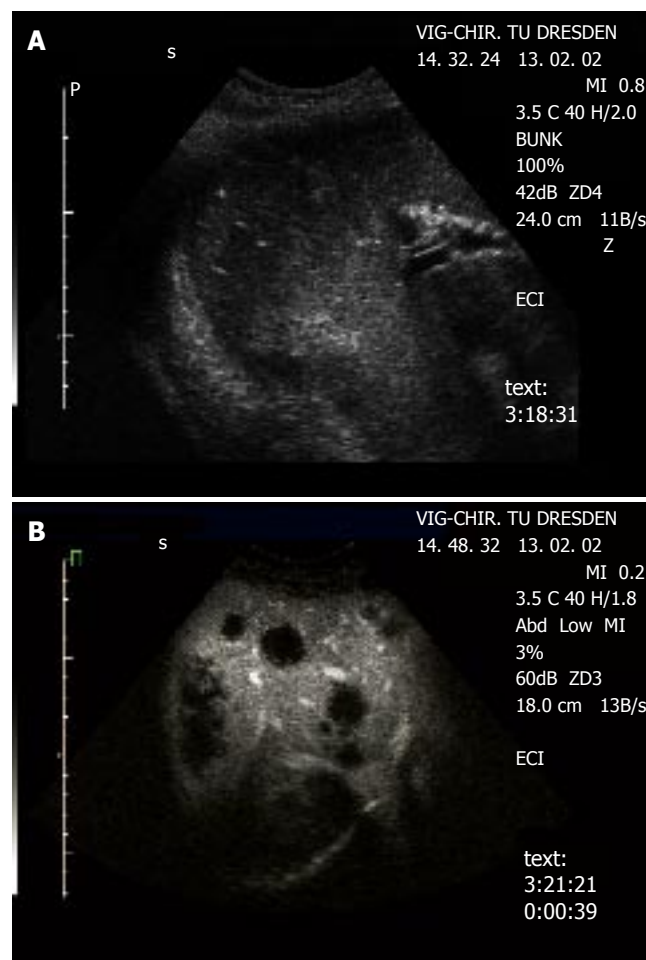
Detection of metastases in a patient with colorectal carcinoma A: Native B-mode sonography revealed 3 metastases (segment 6/7) in agreement with CT, MRI revealed 4 metastases (segment 6/7 and 4). B: Contrast-enhanced sonography identified diffuse metastatic disease in both liver lobes. The metastatic lesions are clearly delineated in the portal-venous phase as 'black spots', due to the lack of portal-venous blood supply.
